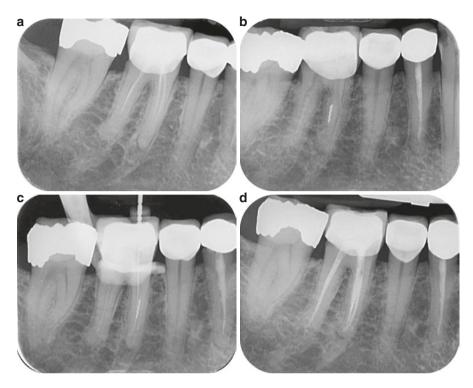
(a) Preoperative radiograph. (b) Fragment at the middle third of the mesiolingual canal of a first mandibular molar. (c) Bypassing of the fragment. (d) Immediate post-obturation radiograph. The fragment can hardly be seen within the obturation material
